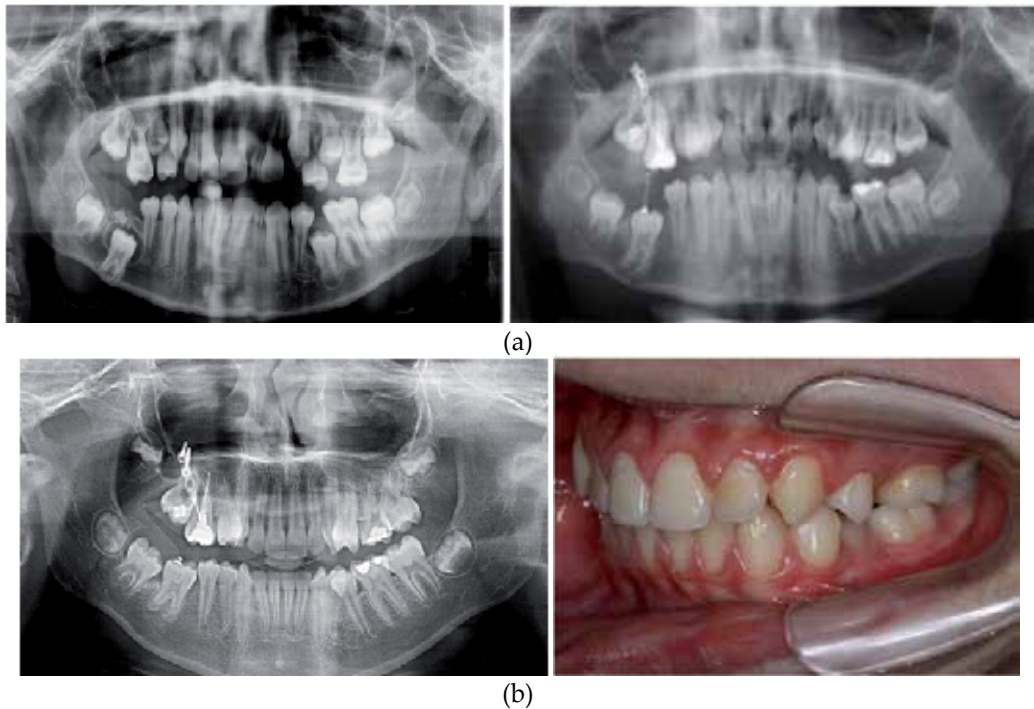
(a): Odontogenic fibroma. Radiograph showing a 12-year-old boy presenting with a posterior mandibular mass associated with an impacted left first molar tooth. (b): Orthodontic extrusion of the impacted first molar using the zygomatic bone anchor and clinical appearance after the right first molar extrusion
